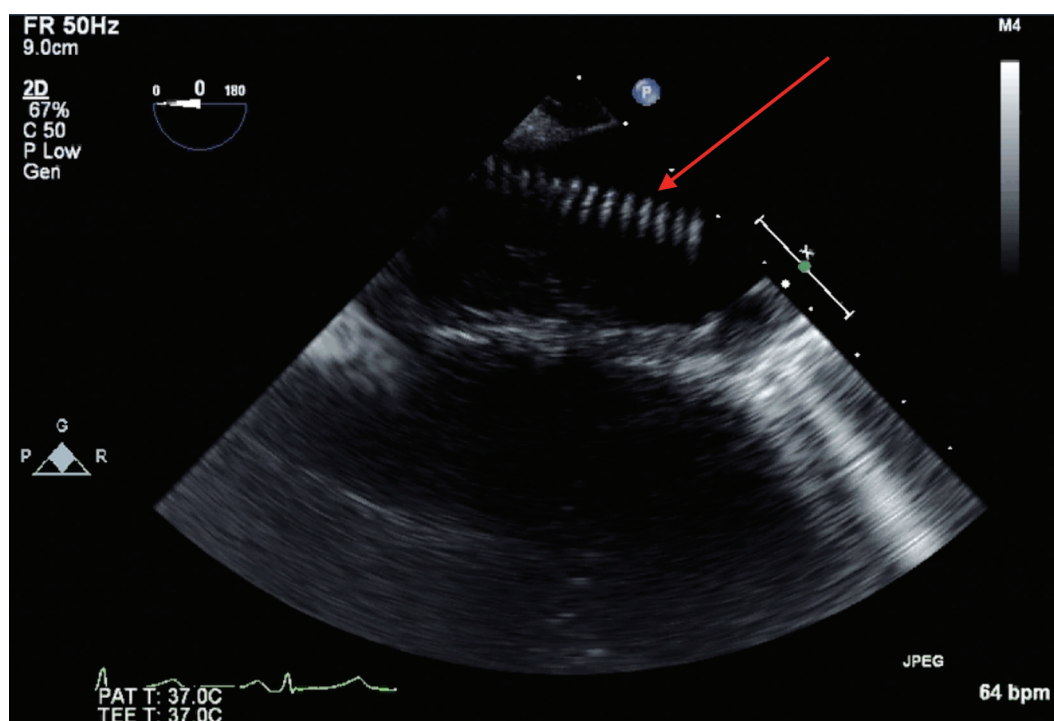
Intraoperative transesophageal echocardiography image showing the elephant trunk graft (indicated by red arrow) in the lumen of the descending aorta. Transesophageal and direct epi-aortic echocardiography confirm appropriate location of the incision for the Finger-Thumb technique.
